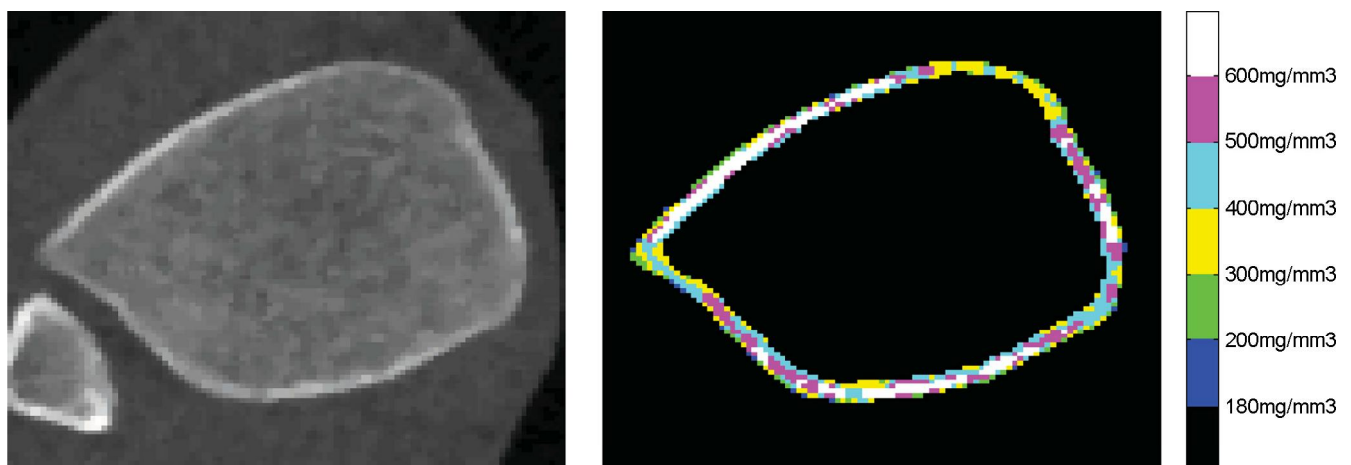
Example of detected CoA: original peripheral quantitative computed tomographic image (left), and corresponding detected CoA with marked bone mineral density distribution (right).
